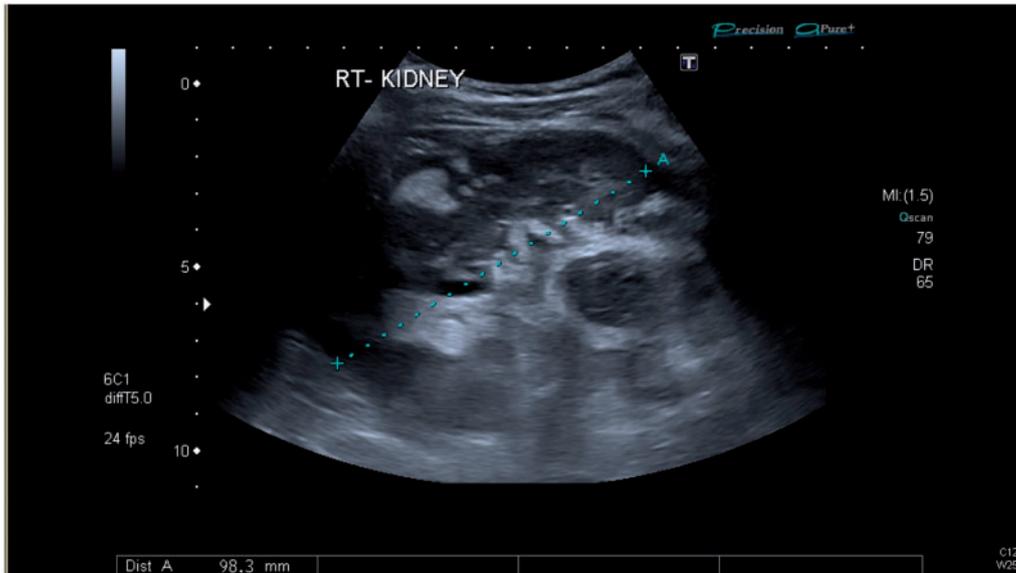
Ultrasound scan of the abdomen showing the right kidney with multiple echogenic areas consistent with multiple AML. The larger, more complex, cystic mass adjacent to the kidney is the haemorrhagic AML.
